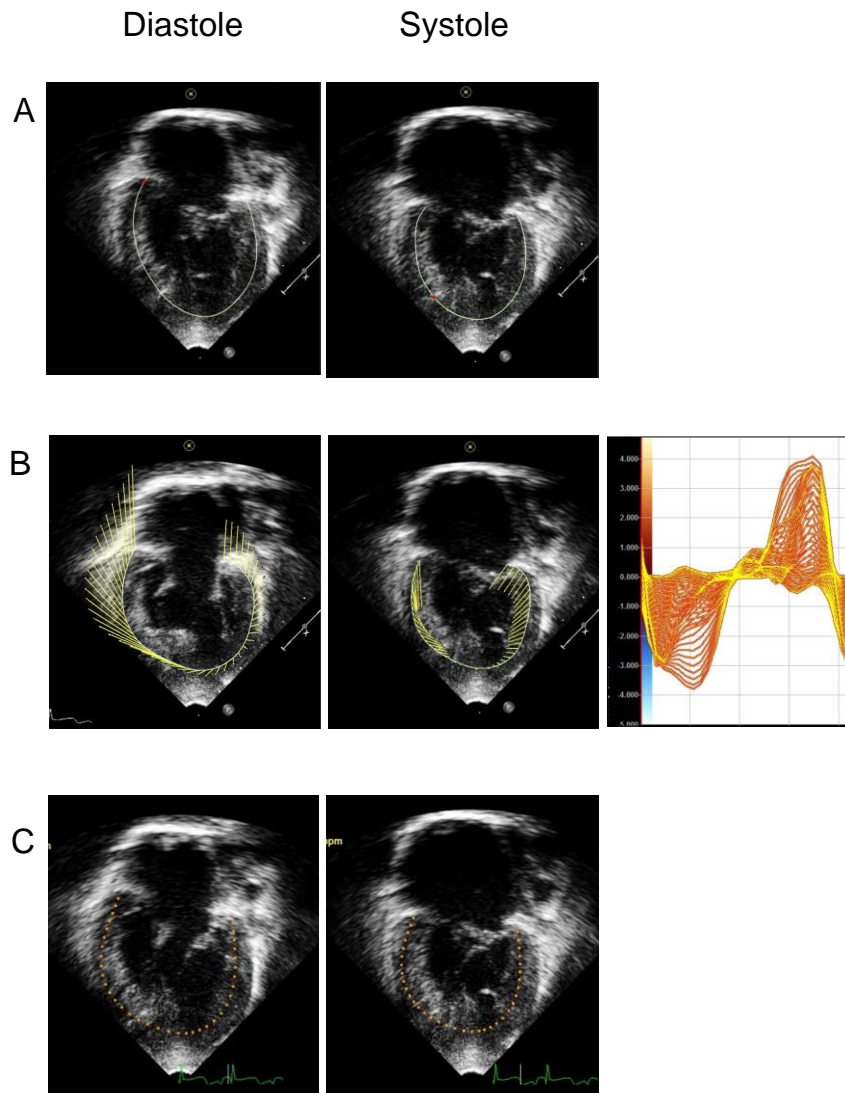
Examples of different echocardiographic based methods to assess myocardial function: a) manual tracing of FAC, b) VVI and c) QLAB.
